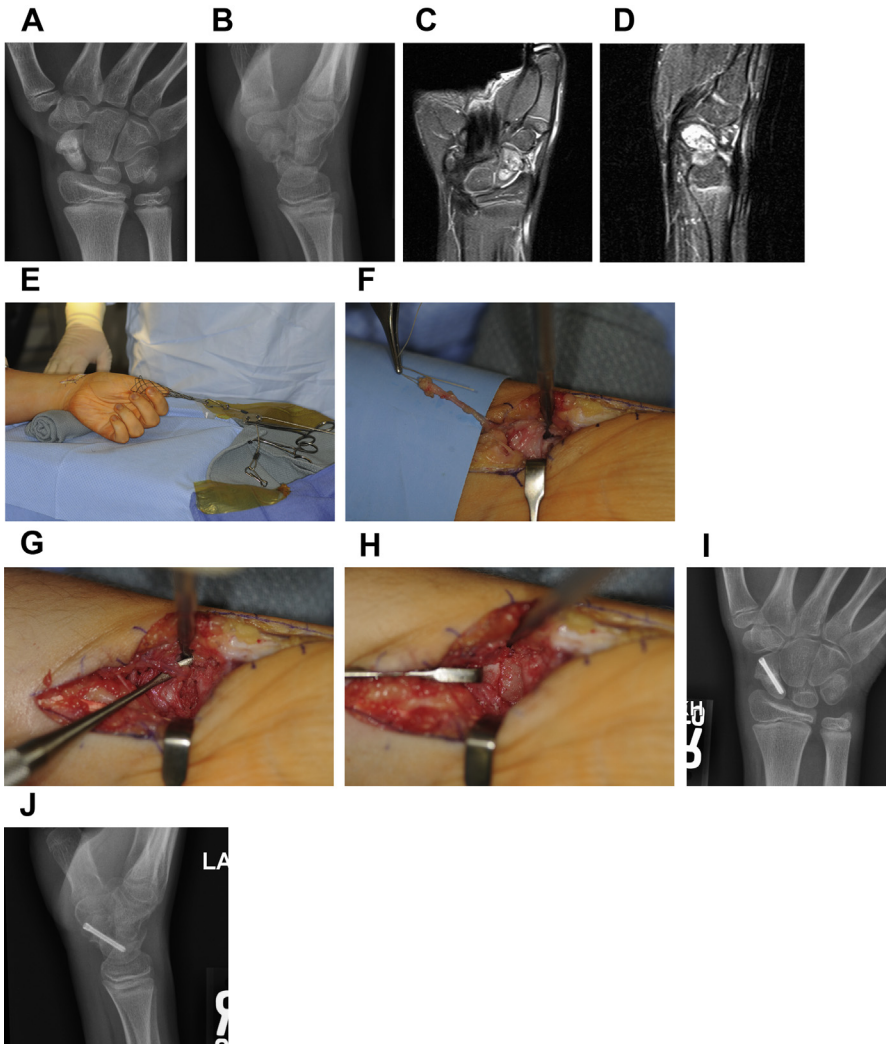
Scaphoid fracture nonunion. Posteroanterior (A) and lateral radiographs (B) and coronal (C) and sagittal MRIs (D) confirmed a nonunion with a humpback deformity. The patient underwent open reduction and internal fixation using traction through the thumb using a fingertrap and a traction table (E). The superficial volar branch of the radial artery (F) was placed into the nonunion site and covered with cancellous bone graft from the distal radial metaphysis (G) with care not to injure the physis. A cortical fragment from the volar distal radius was then used to contain the bone graft and lend structural support to the volar scaphoid during screw compression (H). Six weeks later, the nonunion has healed on posteroanterior (I) and lateral radiographs (J). (Courtesy of Shriners Hospital for Children Philadelphia.)
